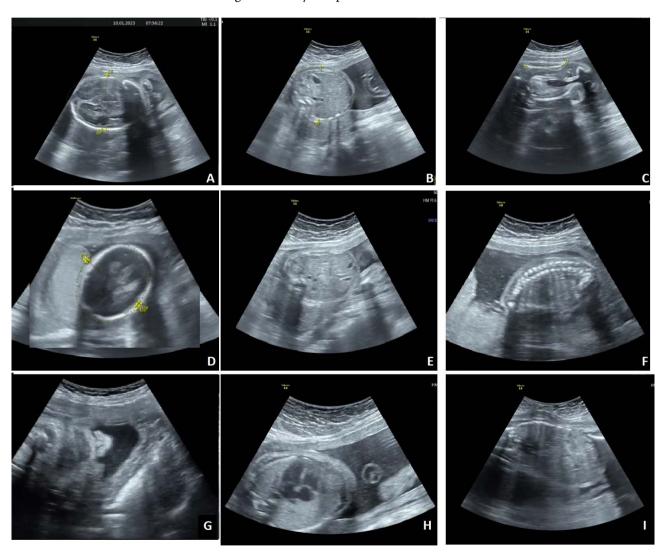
Ultrasound sections without anomalies in the context of a morphological ultrasound. (A) Axial section of the cephalic pole with measurement of the biparietal diameter and cranial circumference; (B) Axial section of the abdomen at the level of the portal sinus showing the abdominal contour; (C) Longitudinal section of the femoral diaphysis; (D) Oblique axial section of the cephalic pole passing through the cerebellum; (E) Axial section of the kidneys at the level of the renal pelvis; (F) Sagittal section showing the spine; (G) Frontal section of the face centered on the nose-mouth; (H) Thoracic axial slice at the level of the 4 cardiac chambers; (I) Para-sagittal thoraco-abdominal section.
